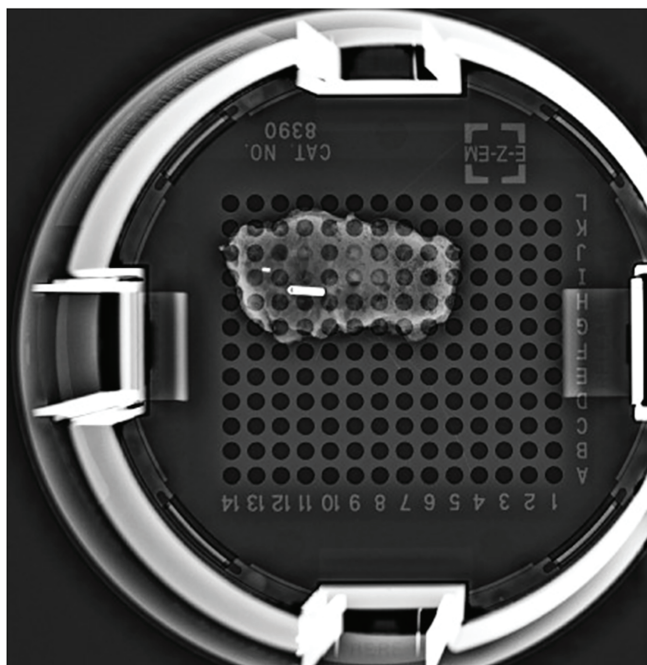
Intraoperative X-ray radiograph showing successful retrieval of the mass and the tags
